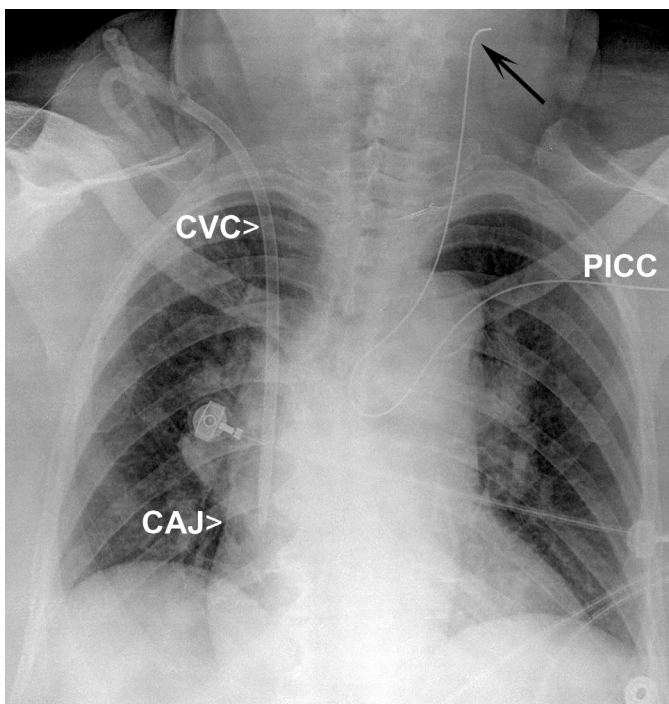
■ Anteroposterior (AP) supine chest x-ray. Left peripheral central venous catheter (PICC) courses cephalad from the left brachiocephalic vein into the left internal jugular vein, with its tip (*arrow*) residing in the mid neck. Note that the guide wire is within the PICC, making it very easy to see. Right internal jugular CVC tip in a good position at the cavoatrial junction (CAJ).
